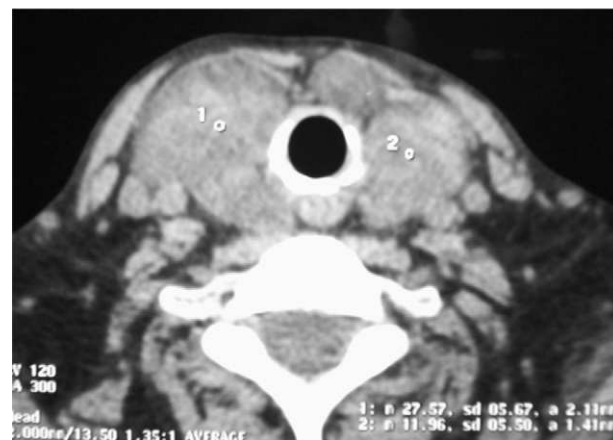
Computed tomography of the neck showing an enlarged thyroid gland with multiple nodules.
